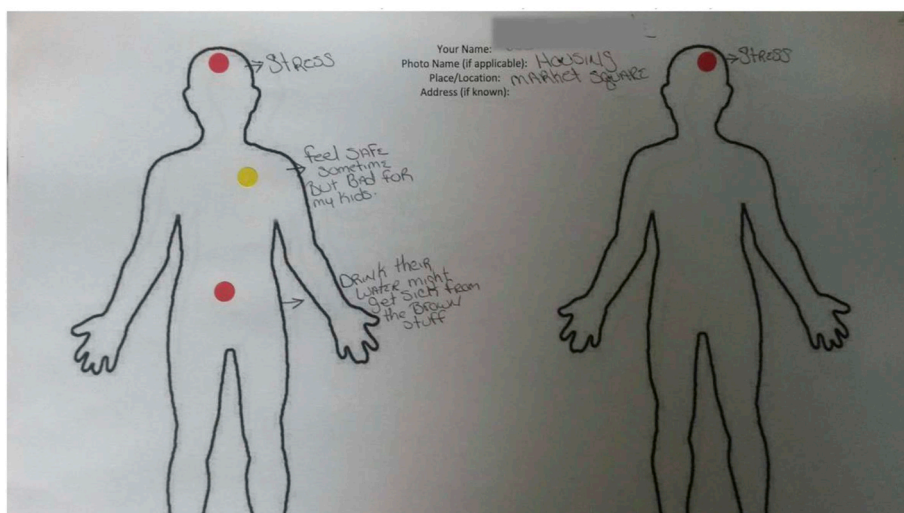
Example of a Completed X-Ray Map. Figure 2: X-Ray Map representing perceptions of place-embodiment related to housing conditions (Adult Participant D).
